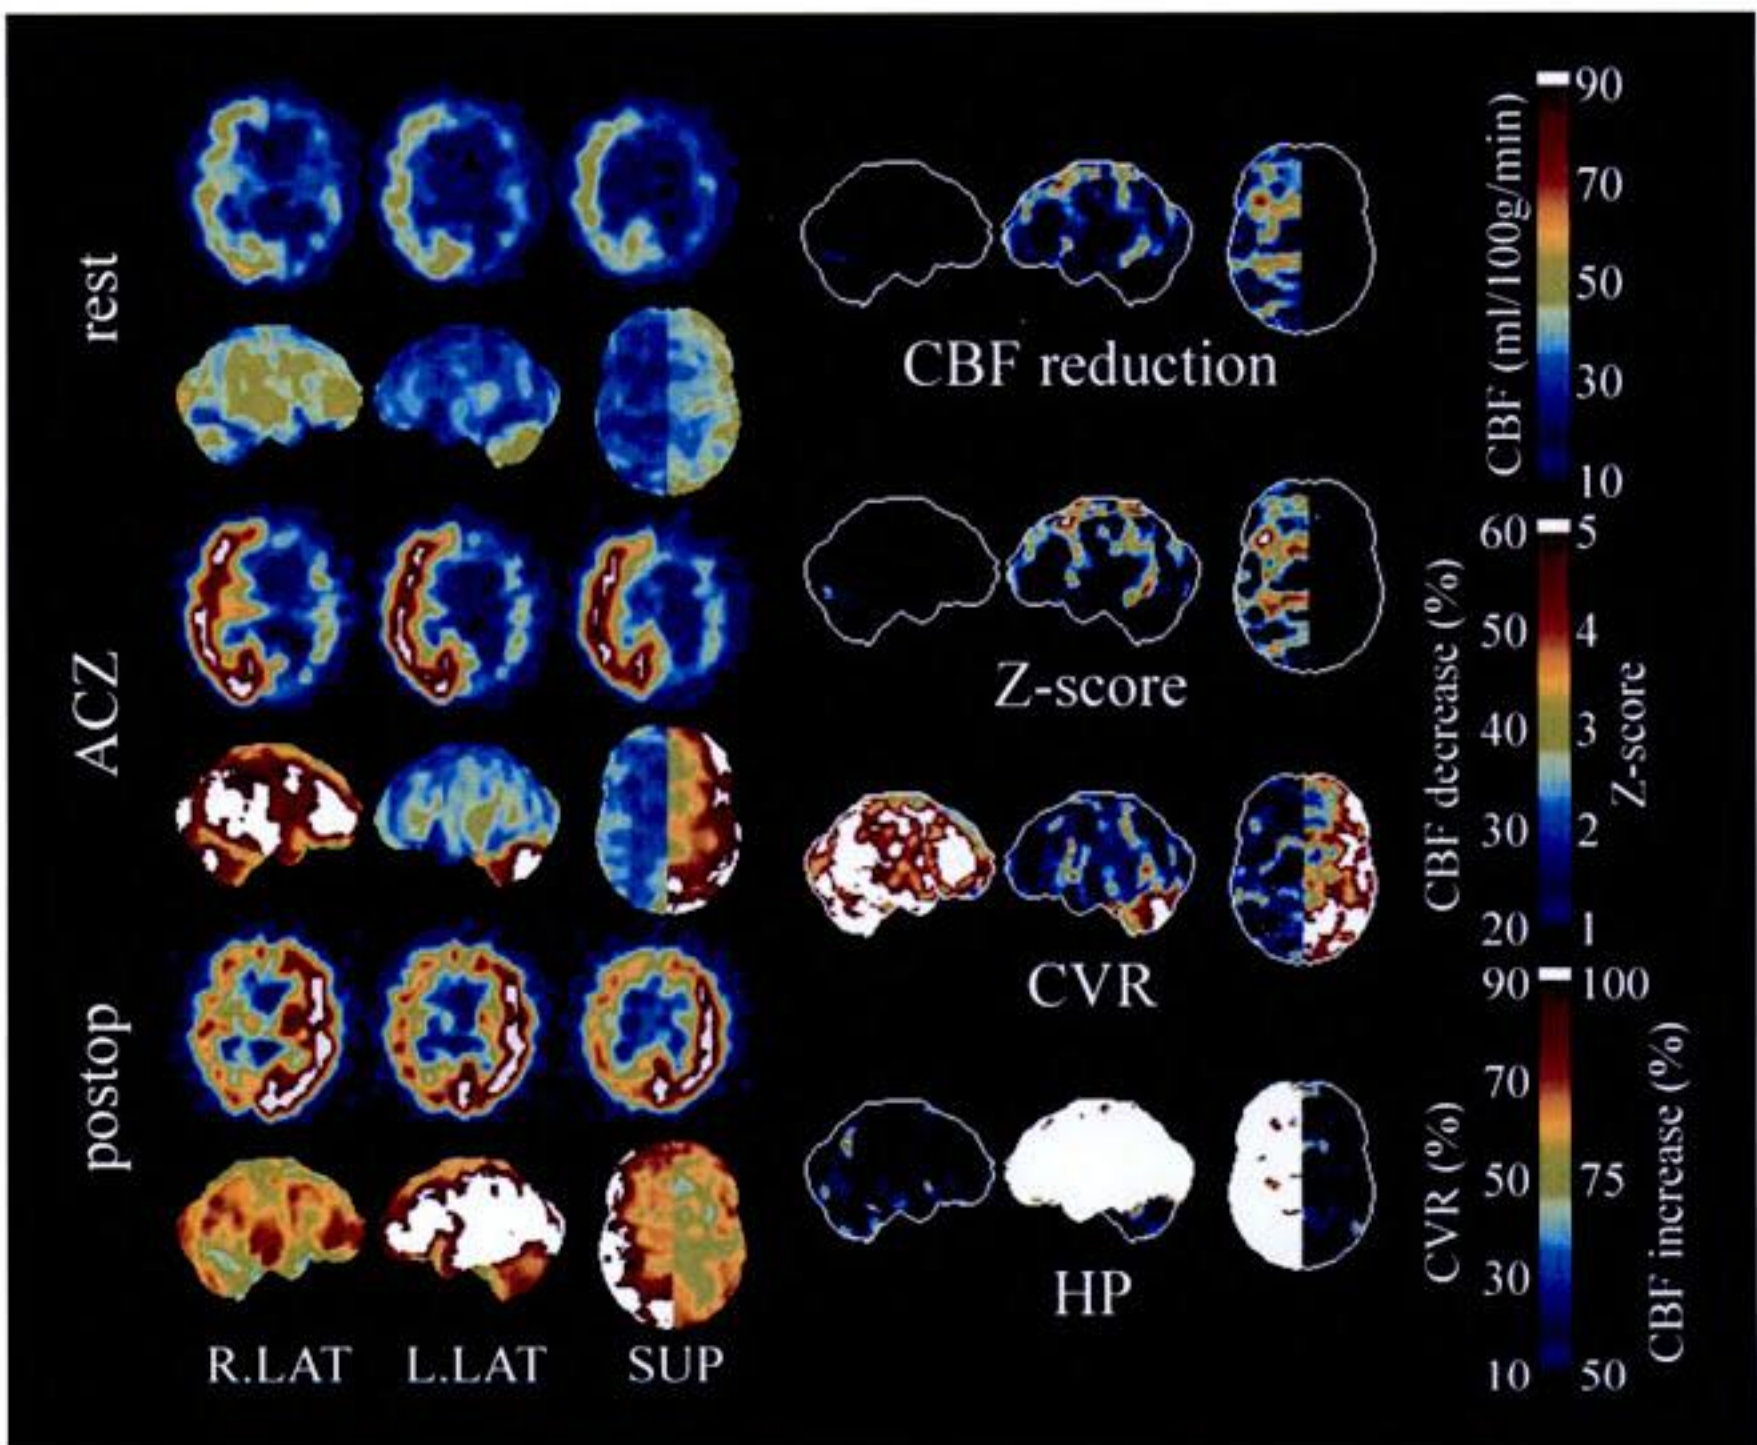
Image analysis of a patient with left carotid stenosis. Left, original SPECT transaxial slices (upper) and cortical surface maps of three-dimensional stereotactic surface projection (3D-SSP) on a pixel-by-pixel basis (lower). Preoperative resting SPECT (rest) demonstrates severe hypoperfusion in the left ICA territory, and acetazolamide (ACZ) challenge SPECT shows low CBF response to acetazolamide in the same territory. Postoperative resting SPECT (postop) demonstrates hyperperfusion in the same territory. Right lateral (R. LAT), left lateral (L. LAT), and superior (SUP) views. Right, cortical surface maps of 3D-SSP. CBF reduction, percent reduction of CBF is displayed on a pixel-by-pixel basis. Z-score, normalized activity of each patient was compared with the reference control database by means of a Z score. A Z score was calculated for each surface pixel: $Z \text{ score} = ([\text{normal mean}] - [\text{individual mean}] / (\text{normal standard deviation}))$. A region with reduced CBF ($z\text{-score} > 2$) is expressed as a colored region and a region with normal CBF ($z\text{-score} \leq 2$) as a black region. CVR, a region with reduced CVR is easily recognized as black pixels. HP, surface maps of CBF percent increase 1 day after CEA. Hyperperfusion is easily recognized as white pixels. CVR: cerebral vasoreactivity.
